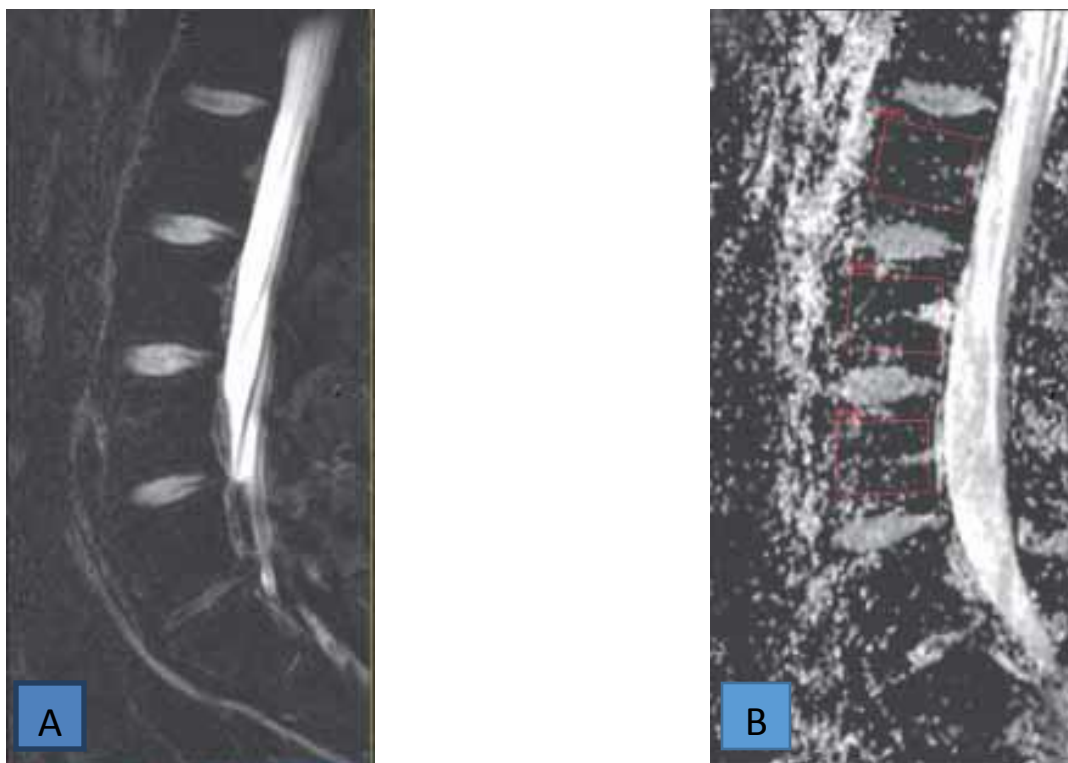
para sagittal MRI of lumbar spine A) Diffusion weighted image. B) Apparent diffusion coefficient (ADC) map.
